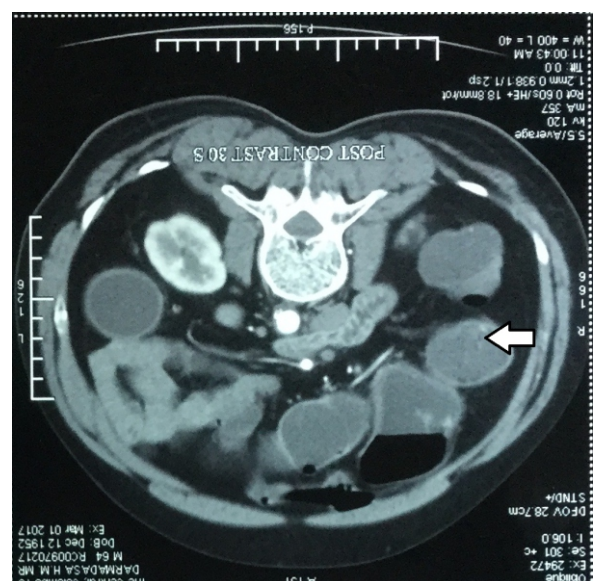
Axial contrast-enhanced Computed Tomography shows small intestines predominantly on right (marked in a white arrow).
